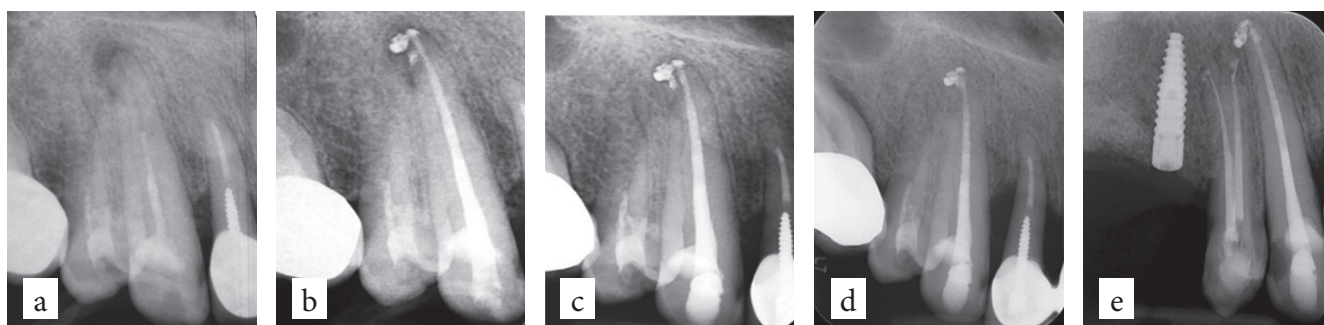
Example of retreatment of mandibular molars with incipient periodontitis (PAI 3). After root canal retreatment, one can see a small overfilling („puff”). After 1 year of root canal retreatment and filling, the lesion has already healed and the 2 years follow-up confirms the result. The overfilling with sealer persists; a – preoperative, PAI 3; b – postoperative radiograph; c – follow-up at 1 year, health; d – follow-up at 2 yrs, health; a – preoperative radiograph, PAI 3; b – postoperative radiograph; c – follow-up at 1 year, uncertain; d – follow-up at 5 yrs, healed; e – follow-up at 7 yrs, healed.
